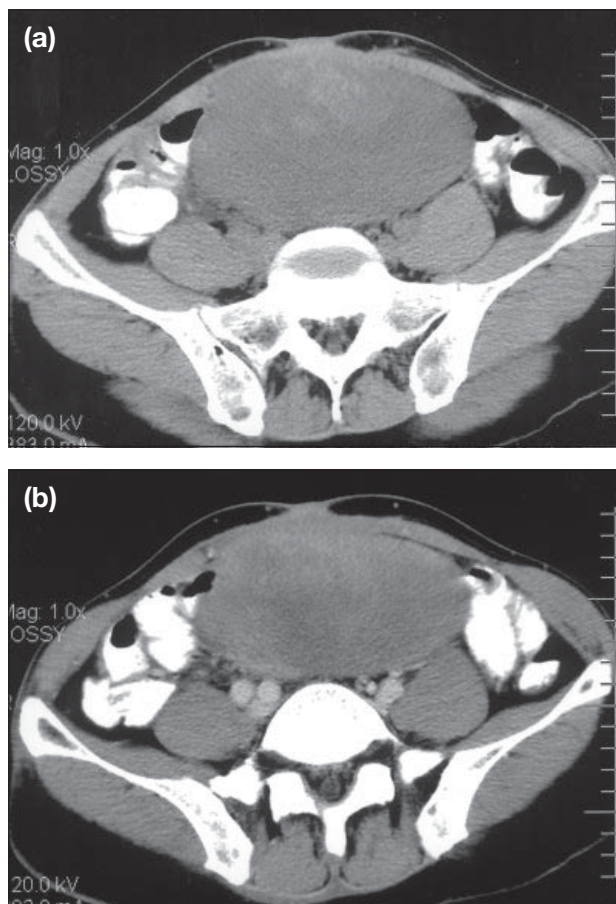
Axial sections of the computed tomography scan (a) with and (b) without contrast demonstrating the well defined large soft tissue tumour mass. It was of mildly mixed density on pre-contrast scan and appeared slightly enhanced with contrast injection.
